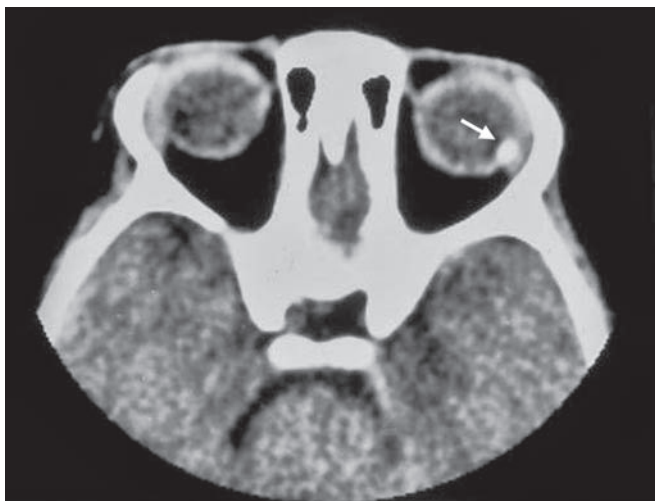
Retinoblastoma left orbit. Unenhanced axial CT scan through the orbits shows a small calcified lesion arising from the retina in the temporal aspect of the left globe (arrow)
